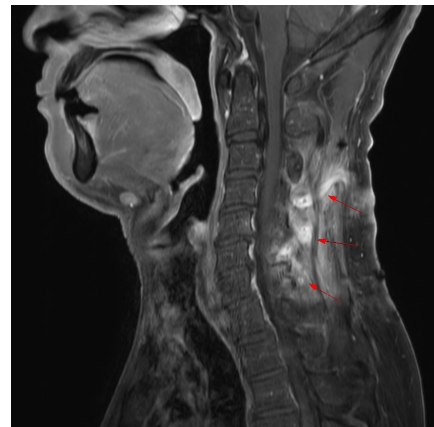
Preoperative magnetic resonance imaging (MRI). T1 sagittal view of contrast enhanced neck MRI showing multiple tubular inflammatory tracts and granulomas.
